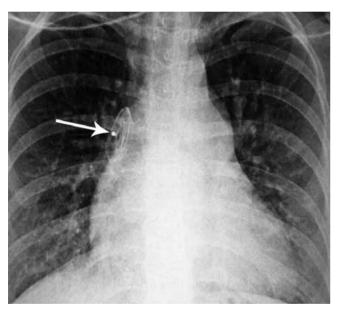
Preoperative chest X-ray of the patient, performed following device embolization. The arrow points very clearly to the septal occluder device in the right pulmonary artery
